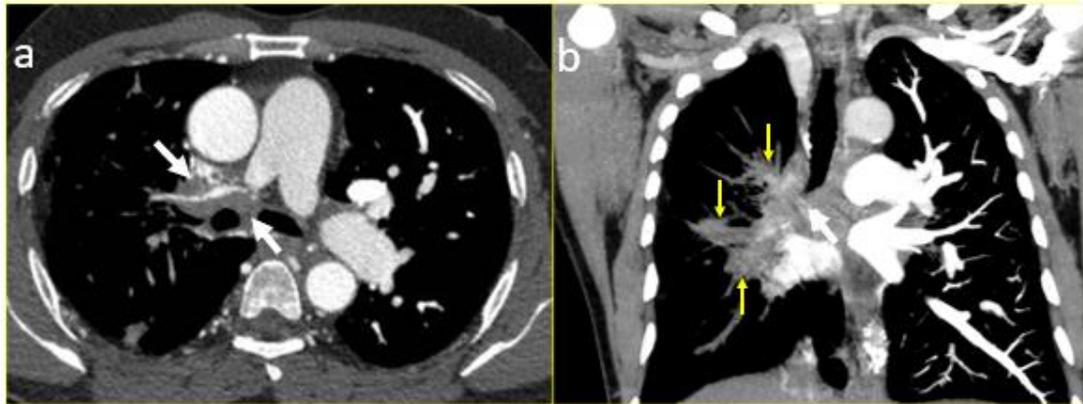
Axial image (a) and Coronal MIP image (b) of CT Pulmonary angiogram show encasement and complete cut off of the right pulmonary artery by a soft tissue mass in the right lower paratracheal and hilar region (white arrows in a and b). The soft tissue also extends into the right peri-bronchial region (yellow arrows in b).
